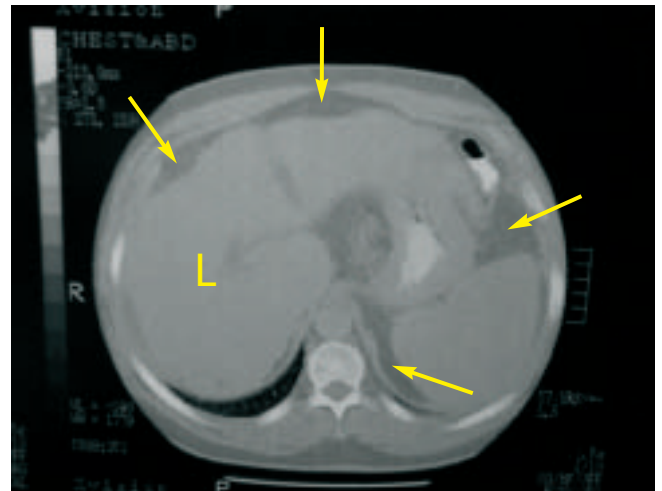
CT scan of the abdomen showing cirrhosis and ascites (arrows). L = liver.
